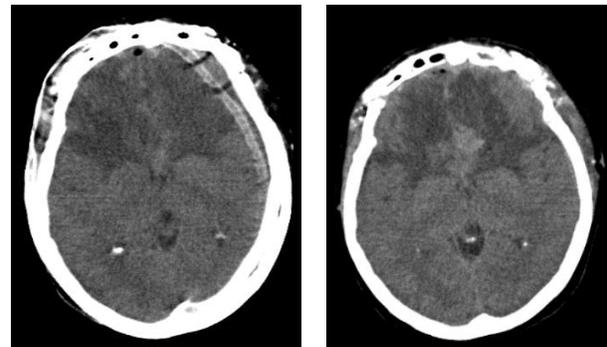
Postoperative CT scans that confirm a total resection of the tumor
